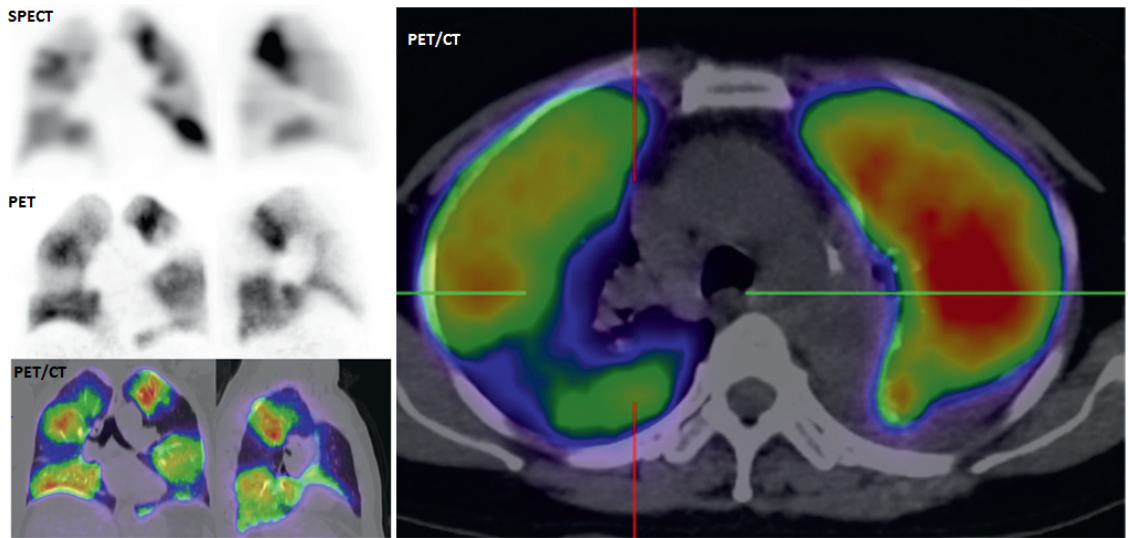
Results for ^{68}Ga -MAA lung perfusion studies showing areas of low perfusion not seen with $^{99\text{m}}\text{Tc}$ -MAA SPECT (62).
